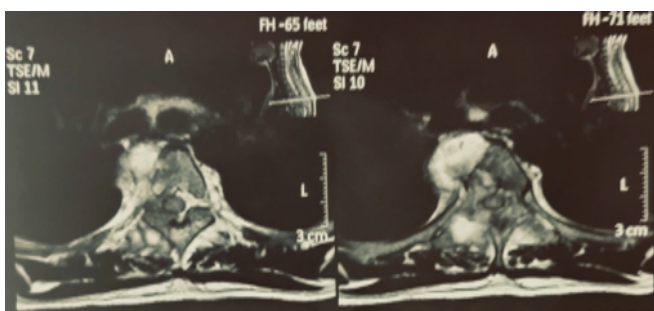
MR imaging of the whole spine in the transverse section reveals Infective spondylodiscitis extending into the anterior and posterior epidural spaces with severe spinal cord compression
